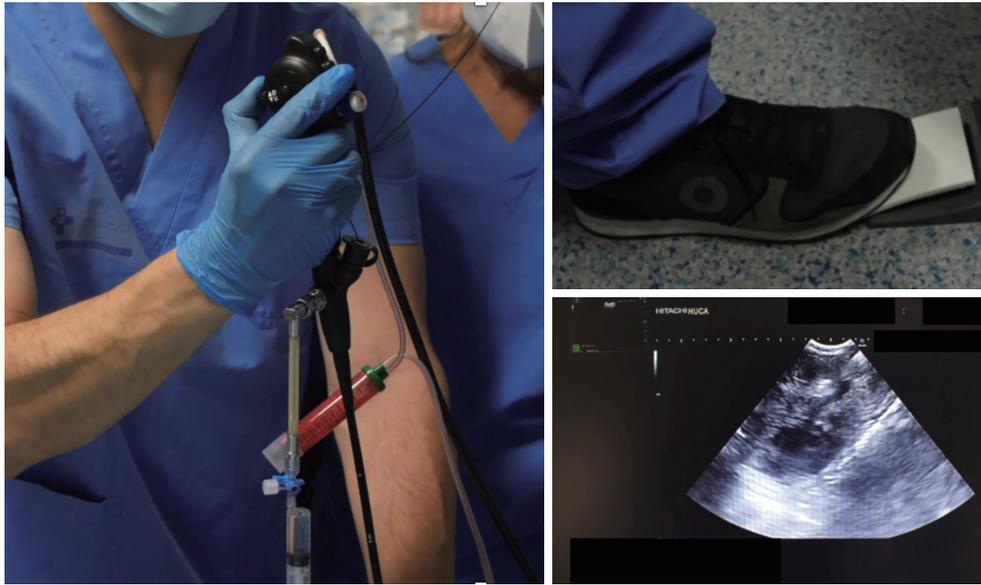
The Cryoprobe firmly grasped with the fourth and fifth fingers, once fixed, the lever of the EBUS scope should be in neutral position. The pedal needs to be pressed for 3–5 seconds until the sample is secured outside the airway. EBUS, endobronchial ultrasound.
